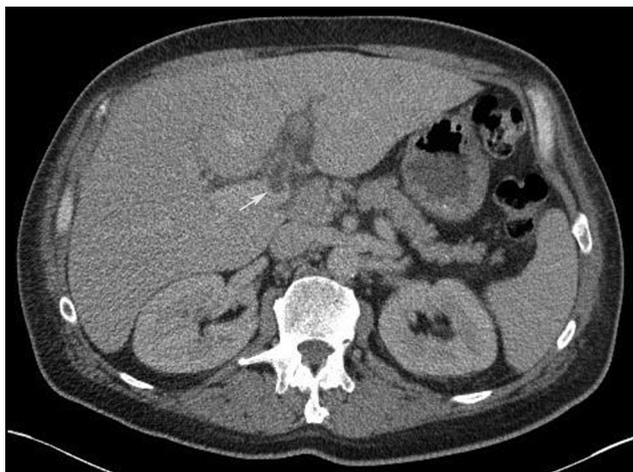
The white arrow on this CT scan of the abdomen indicates a filling defect in the portal vein.
